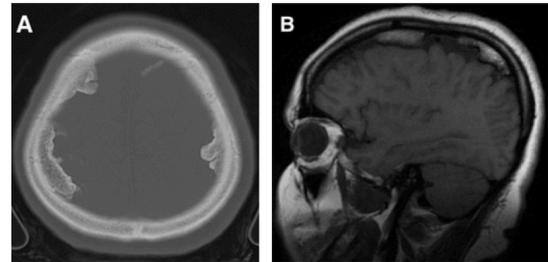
(A) CT scan, hyperdensity next to the skull, showing bilateral subdural chronic calcification; (B) MRI sagittal view of calcification in subdural space.
